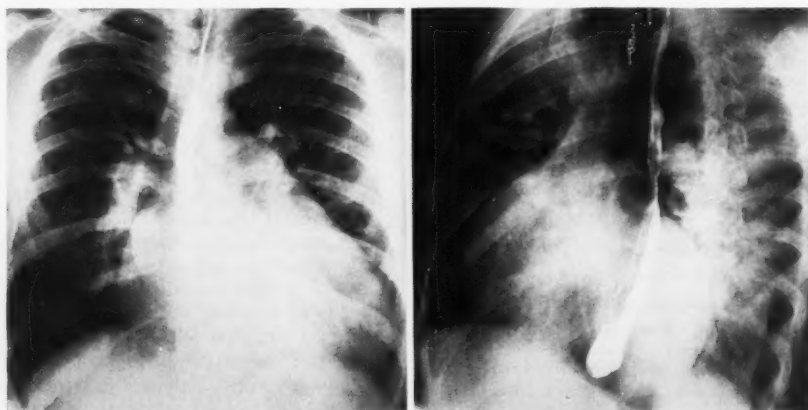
X-rays of the heart, demonstrating generalized chamber enlargement; P.A. and left anterior oblique views shown. The pulmonary artery and left ventricle are prominent, with a small aortic knob.
